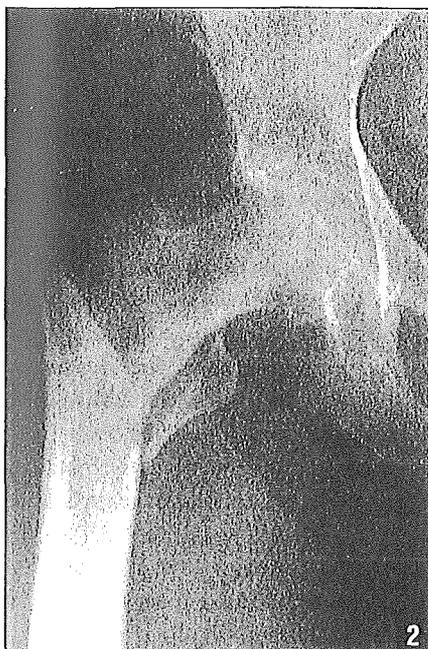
Intertrochanteric fracture Kyle type III. Figure 3: Radiograph control 14 months after surgery shows good healing of fracture.
